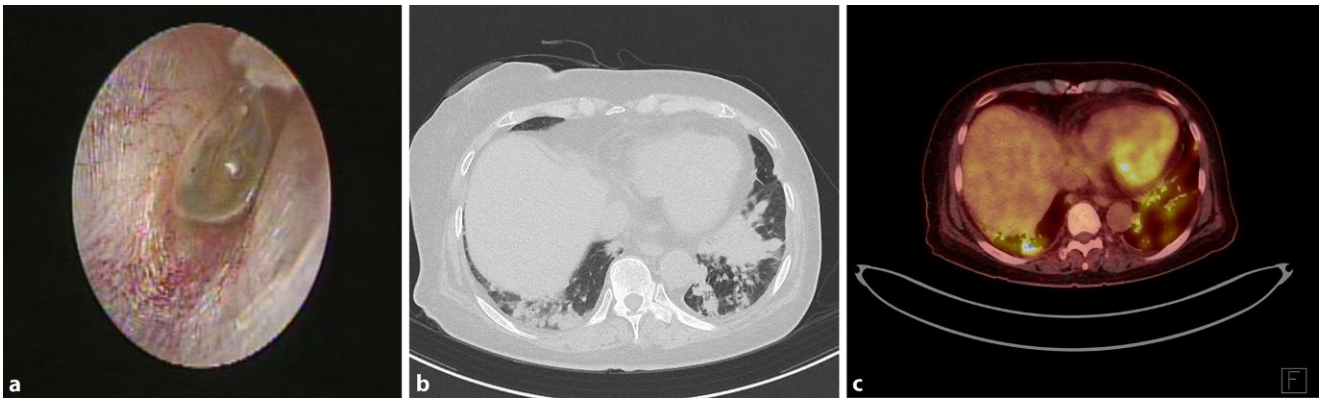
▲ a tympanogram of the left ear with effusion of tympanic membranes; b computed tomography (CT) image of the chest showing variable sized enhancing nodules in both lungs, with lower lung zone predominance; c positron-emission tomography/CT image
